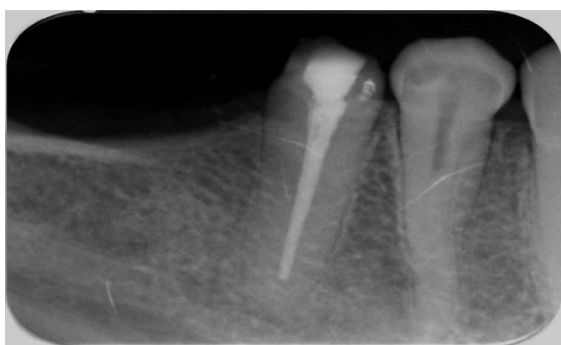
Periapical image
